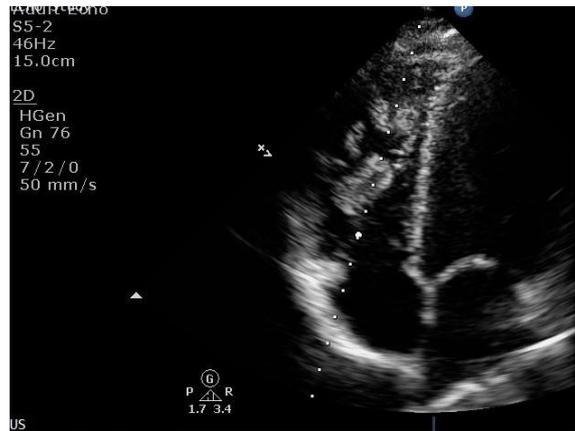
TTE apical 4-chamber view
